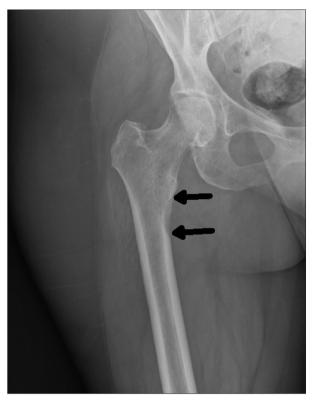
X-radiograph of the right femur. A lytic lesion is present in the medial subtrochanteric proximal femoral diaphysis (arrows).
